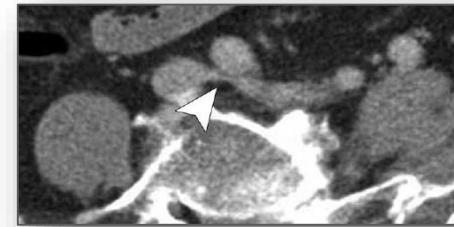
Phlebo-CT demonstrating focal compression of the common iliac vein.
